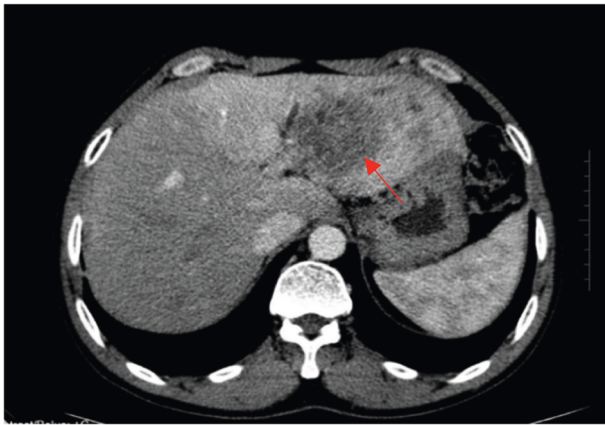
Spiral CT scan of the portal vein, inferior vena cava, and hepatic artery showing “pseudocapsule” features suspicious for hepatocellular carcinoma.
